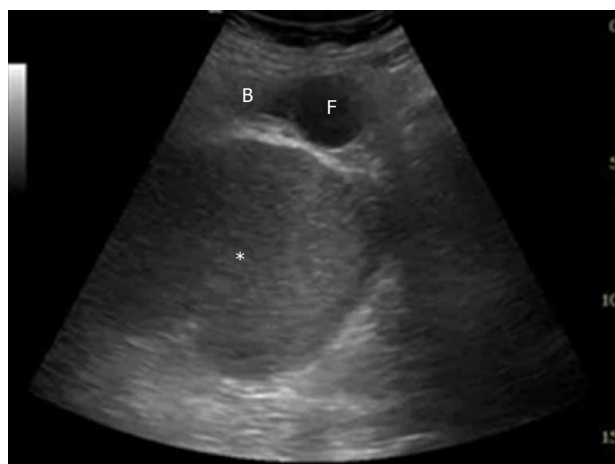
Bladder ultrasonography revealed a pelvic cystic lesion (asterisk) with mass effect on the bladder. B: Bladder; F: Foley.
